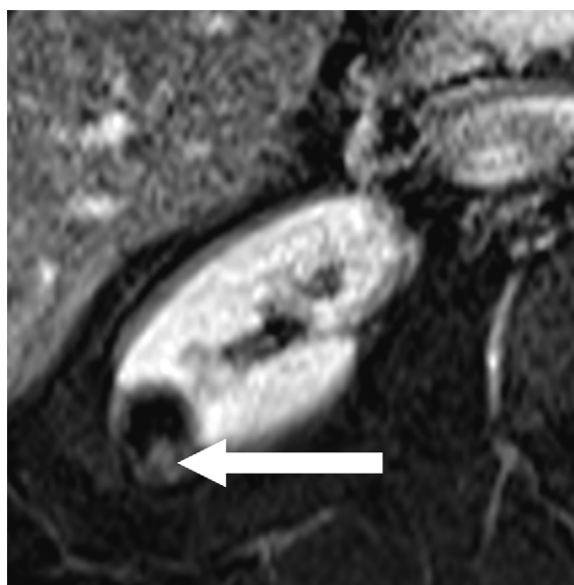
Cystic ccRCC in a 65-year-old man. Coronal postcontrast delayed phase T1-weighted MR image shows a cystic right lower pole renal mass best characterized by using the Bosniak classification system (version 2019) for cystic renal masses, with a Bosniak IV category determined on the basis of the presence of an enhancing nodule (convex protrusion with acute margins) larger than or equal to 4 mm (arrow). The ccLS should not be applied to cystic renal masses, defined as having less than 25% solid enhancing component. Grade 1 ccRCC was found at partial nephrectomy.
